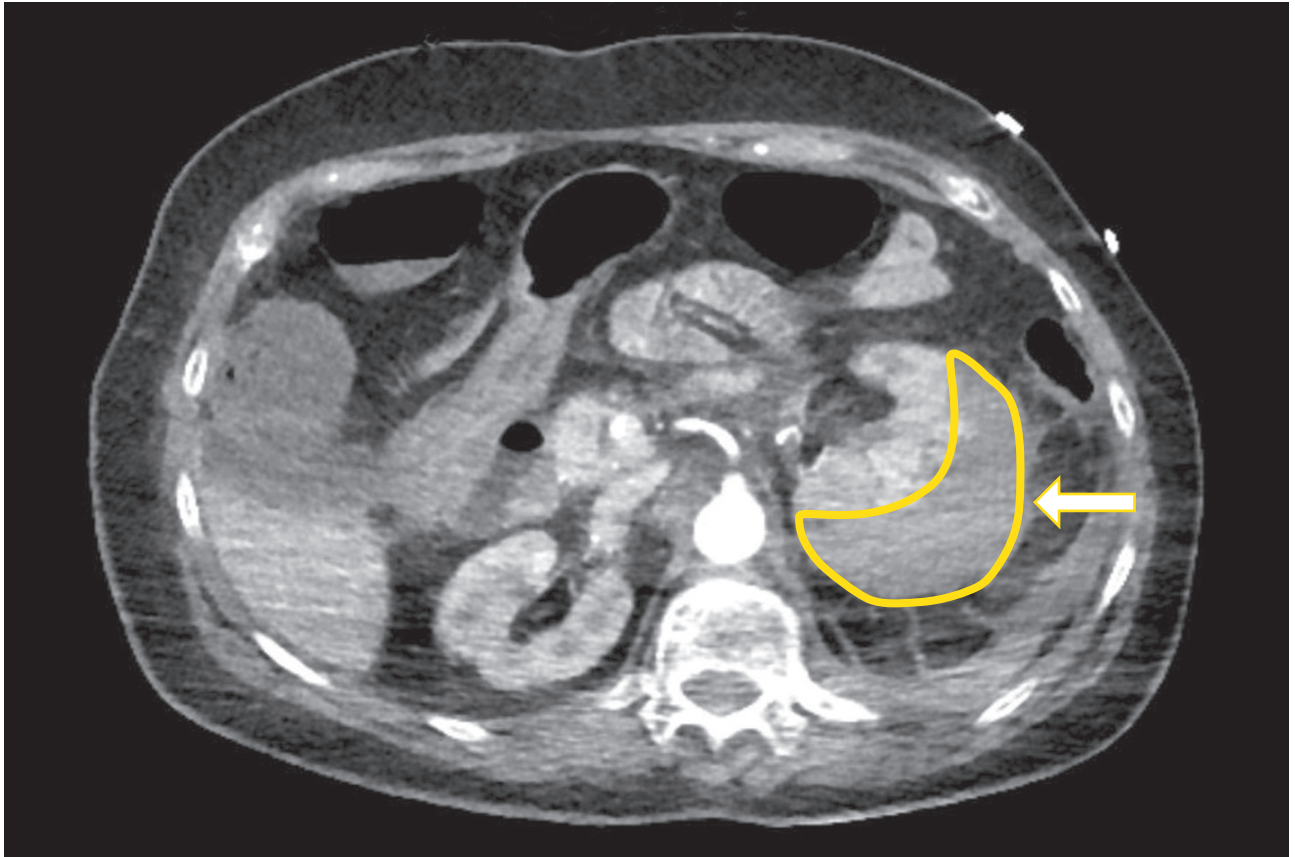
Abdominal computed tomography (transverse plane) with extensive left perirenal haemorrhage (yellow outline; yellow arrow)
